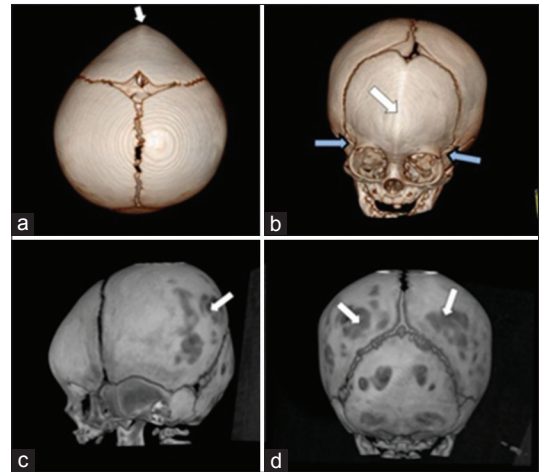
Multidetector computed tomography volume rendering technique images showing (a and b) midline frontal eminence (white arrow) and bitemporal indentations (blue arrows) (c and d) gyral impressions on calvarial and bilateral parieto-occipital regions (arrows)
